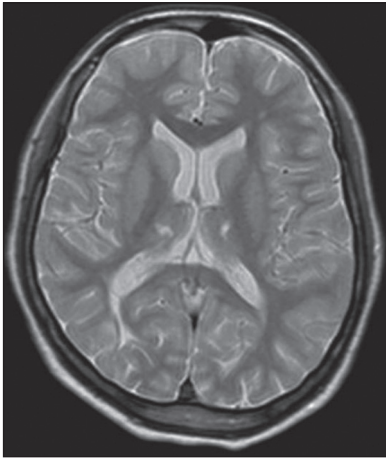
T2 weight magnetic resonance imaging (MRI) of a 16-year-old girl who had a history of high grade fever, with seizures associated with unconsciousness 10 years back, who later presented with upper limb dystonia and choreoathetoid movements years. MRI shows hyperintensities in bilateral thalami
